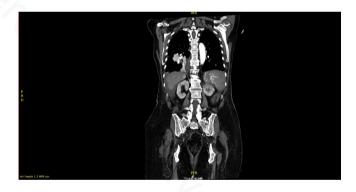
Coronal section of CT Abdomen showing hemoperitoneum and laceration of the spleen.
